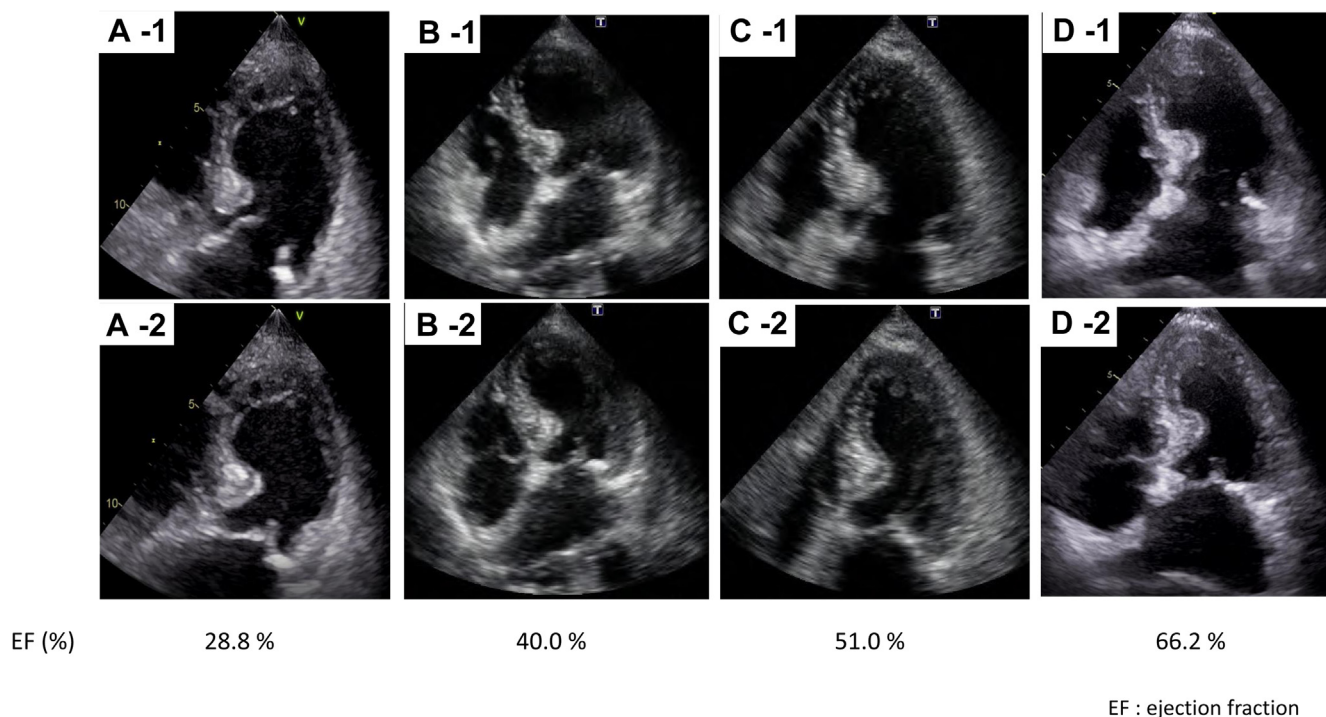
Transthoracic echocardiogram results (A) during (A1) diastole and (A2) systole at the onset of Takotsubo cardiomyopathy revealing apical hypokinesis; (B) during (B1) diastole and (B2) systole 1 week after the onset revealing the improvement of cardiac function; (C) during (C1) diastole and (C2) systole 9 days after the onset; and (D) during (D1) diastole and (D2) systole 1 month after the onset revealing the improvement to reference range.
